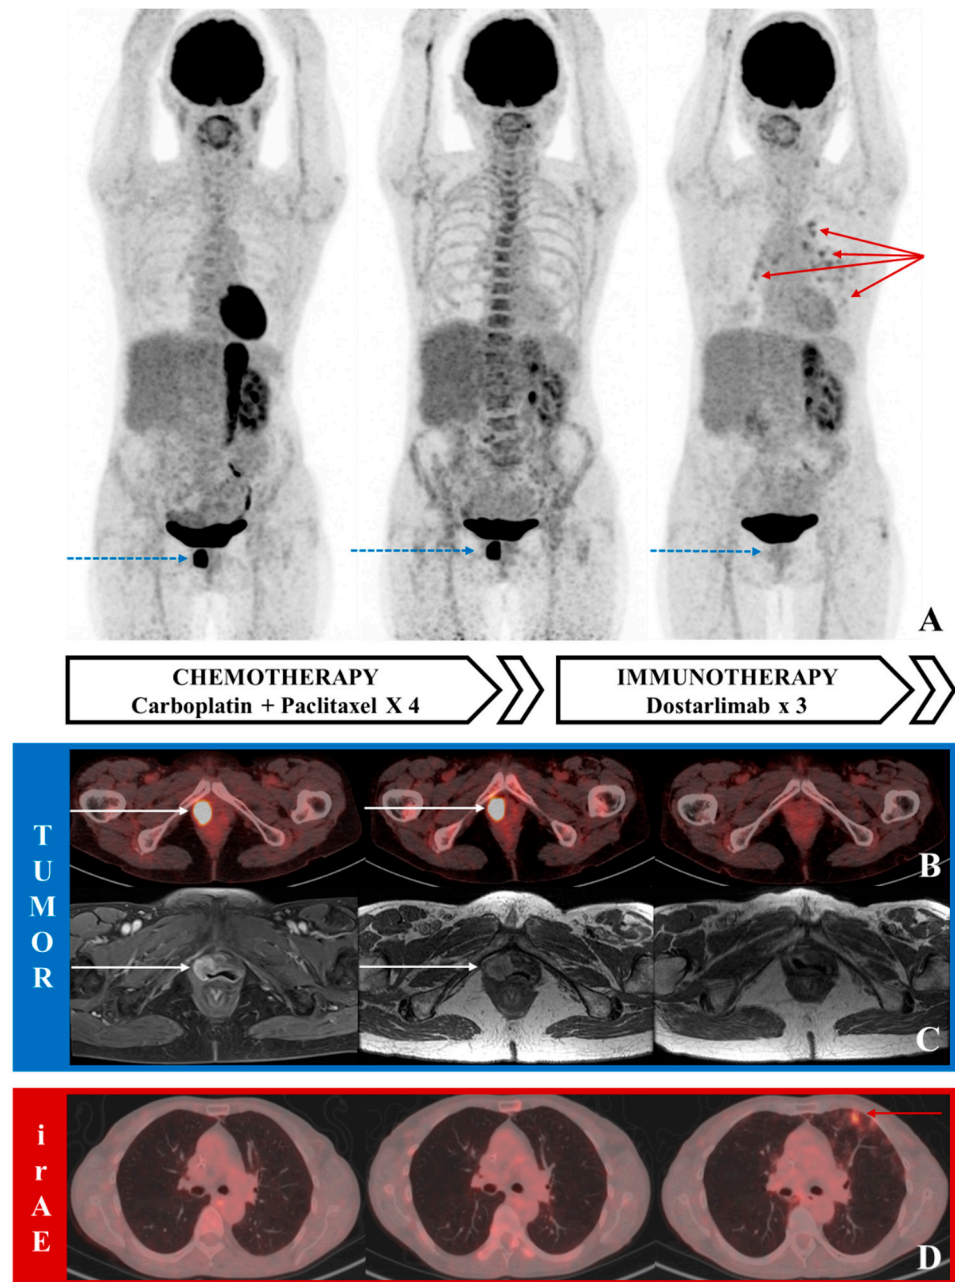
^{18}F -FDG PET/CT images and axial T1 gadolinium-enhanced pelvic MRI (with fat-saturation for the left image and without for the two others, because fat-saturation technique was not available/performed) at recurrence and follow-up during chemotherapy and immunotherapy showing pathological FDG uptake (A: maximum intensity projection-MIP PET images; B: fused axial PET/CT images) and contrast enhancement (C) corresponding to the tumor lesion in the vagina (blue arrows on the MIP, white arrows on ^{18}F -FDG PET/CT and MRI images), without any metabolic or morphologic changes under chemotherapy. After three injections of dostarlimab, a complete response was observed both on pelvic MRI and ^{18}F -FDG PET/CT, associated with irAE (immune-related adverse event) pneumonitis, suggested by hypermetabolic peripheral reticular markings (red arrows on the MIP and ^{18}F -FDG PET/CT images) and small ground-glass opacities (D), then confirmed by bronchoalveolar lavage.
